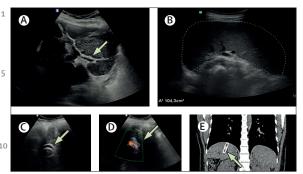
Imaging features of the patient and TIPS implant (A) Ultrasonography of the liver showing irregular surface and periportal fibrosis (arrow) with highly echogenic bands and streaks, extending from the portal vein bifurcation to the liver surface (pattern F of the Niamey-Belo Horizonte classification⁷). (B) Ultrasonography of the spleen showing severe splenomegaly. (C) Ultrasonography of the liver showing the TIPS device (arrow). (D) Colour doppler ultrasonography of the liver showing pervious TIPS device (arrow). (E) CT scan showing the TIPS device in the liver (arrow). TIPS=transjugular intrahepatic portosystemic shunt.
